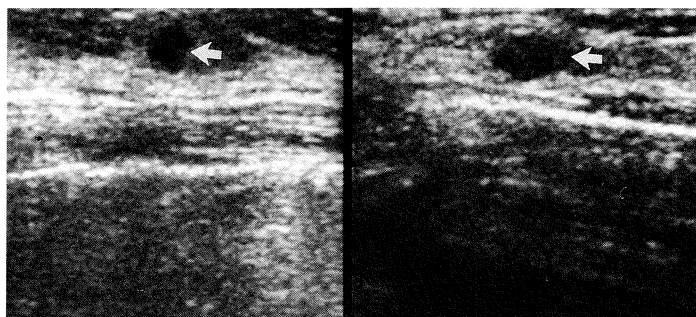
Ultrasound scans of the breasts.
